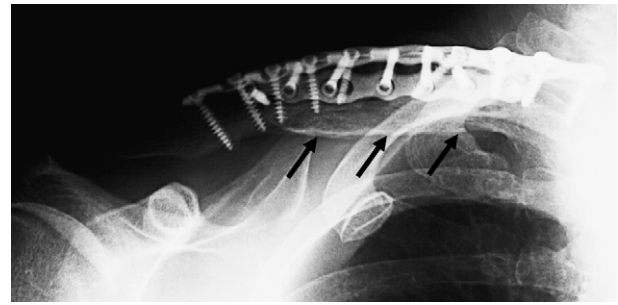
Radiograph shows results at 40 months after the final fixation surgery and just before metal removal. Hypertrophic callus has increased the final diameter of the midshaft clavicle to nearly 3 times greater than that of the patient's left clavicle. The arrows indicate the lower edge of the healed bone.
